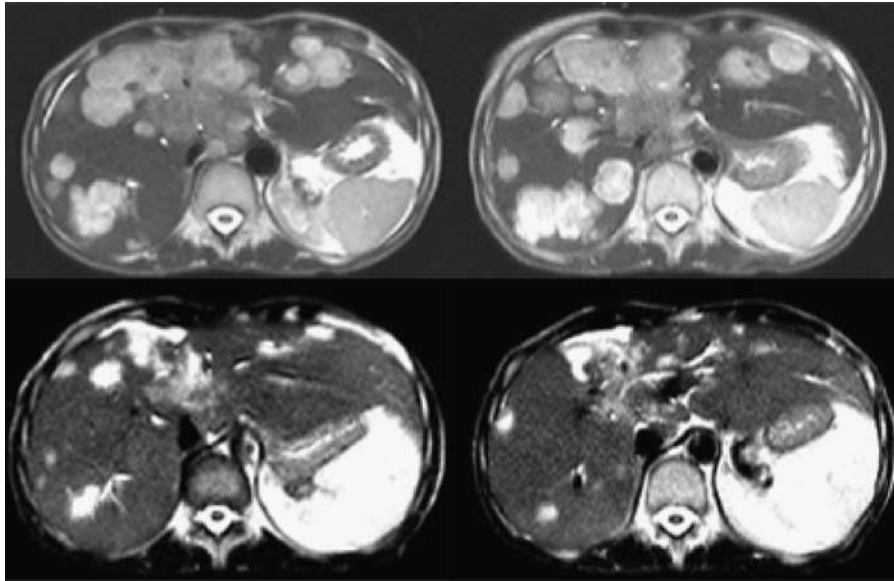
Abdomen T2-weighted MRI of day +220 after NST showing liver disease progression (upper images). Partial disease remission on day +288 after the addition of paclitaxel to trastuzumab (lower images).
